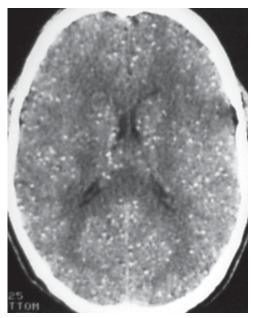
CT of brain showing a "starry night appearance" in a patient of neurocysticercosis with massive parasitic load
